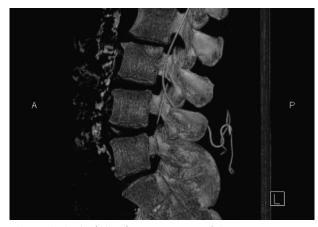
Sagittal view from reconstructed CT scan demonstrating intact and sheared intrathecal catheters.
